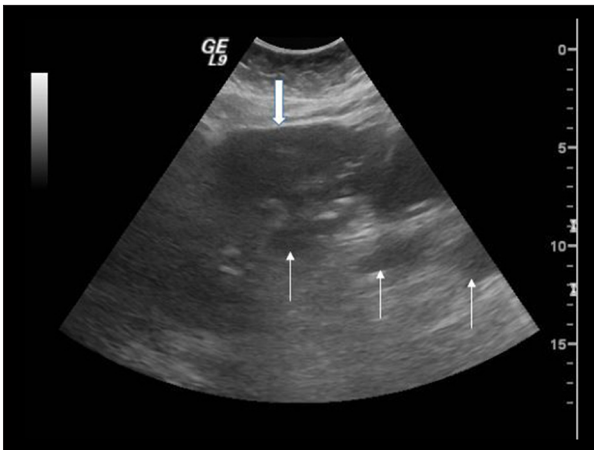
Ultrasound of the right upper quadrant showing an edematous, emphysematous gallbladder (thick white arrow) along with multiple echogenic foci in the left liver lobe suggestive of air in biliary tract (thin arrows).
